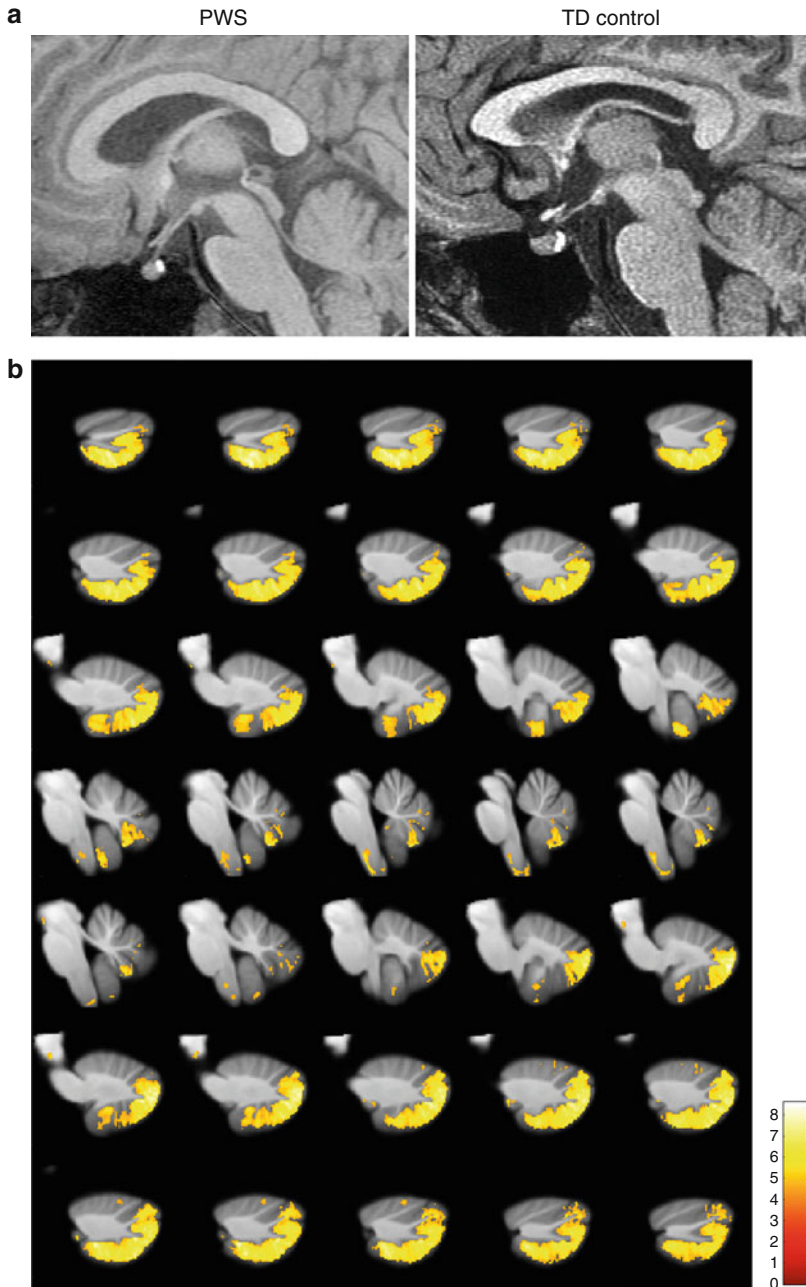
Magnetic resonance imaging findings of subcortical structures in individuals with Prader-Willi syndrome. (a) Representative focused pituitary gland structural T₁ contrast magnetic resonance images (T₁ MRI) showing the anterior and posterior part of the pituitary gland from an adult individual with Prader-Willi syndrome (PWS) and an adult individual with typical
